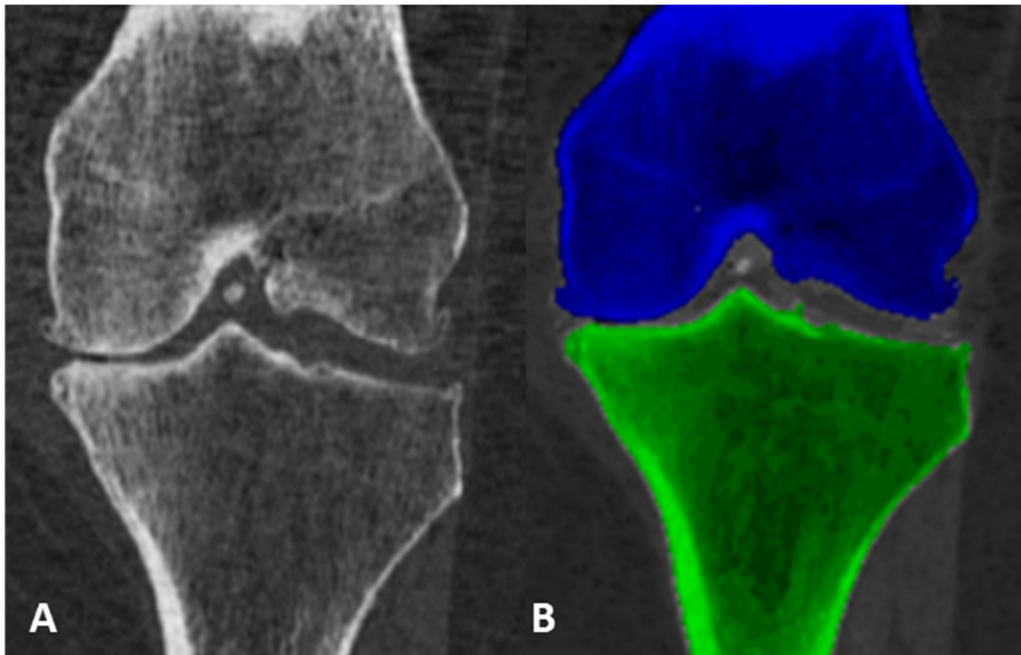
(A) CT image of the knee. (B) Segmented bones of the knee. Image shows femur (blue) and tibia (green) in coronal reconstruction of CT image.
